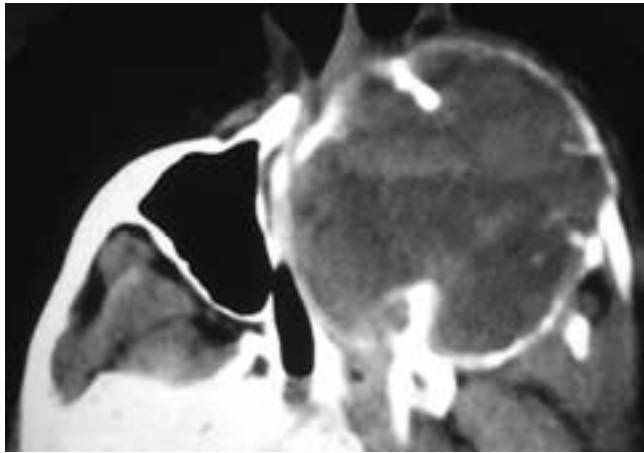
Axial CT scan shows an expansile mass in the left maxillary sinus. The surrounding bone is remodeled and not eroded. This patient had an aneurysmal bone cyst. (Courtesy of Dr. Revel and Dr. Vanel.)
